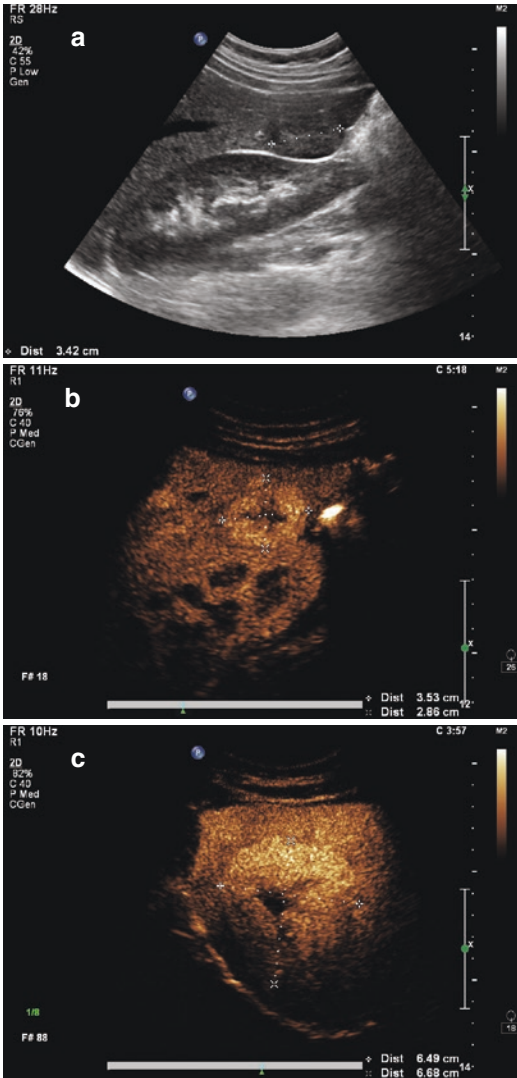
A 17-year-old girl with history of treated neuroblastoma and multiple focal nodular hyperplasia (FNH) nodules. (a) Conventional sagittal grayscale ultrasound image shows a hypoechoic solid nodule in segment 6 of the liver (cursors). (b) Sagittal contrast-enhanced ultrasound (CEUS) image obtained during the portal venous phase shows the nodule is hyperenhancing and has a central scar (cursors). (c) A second, larger FNH in segments 7 and 8 (cursors) shows similar enhancement features. The lesions did not wash out on delayed phase imaging. These CEUS features are typical of FNH
